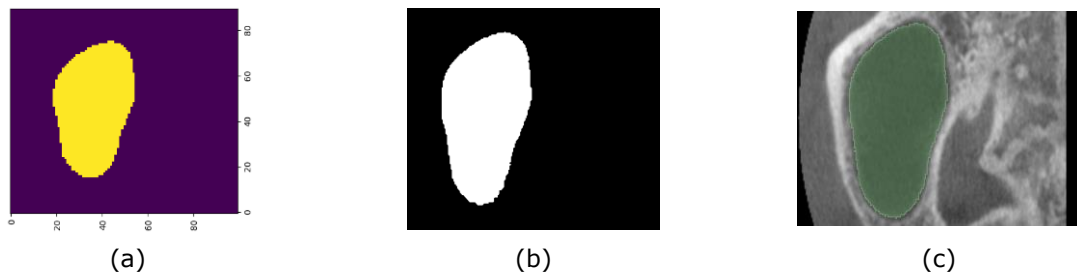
Data conversion: (a) NIfTI data, (b) DICOM data, and (c) Use 3D Slicer to superimpose the prediction results on the raw CBCT image (the green part in image is the prediction results).
